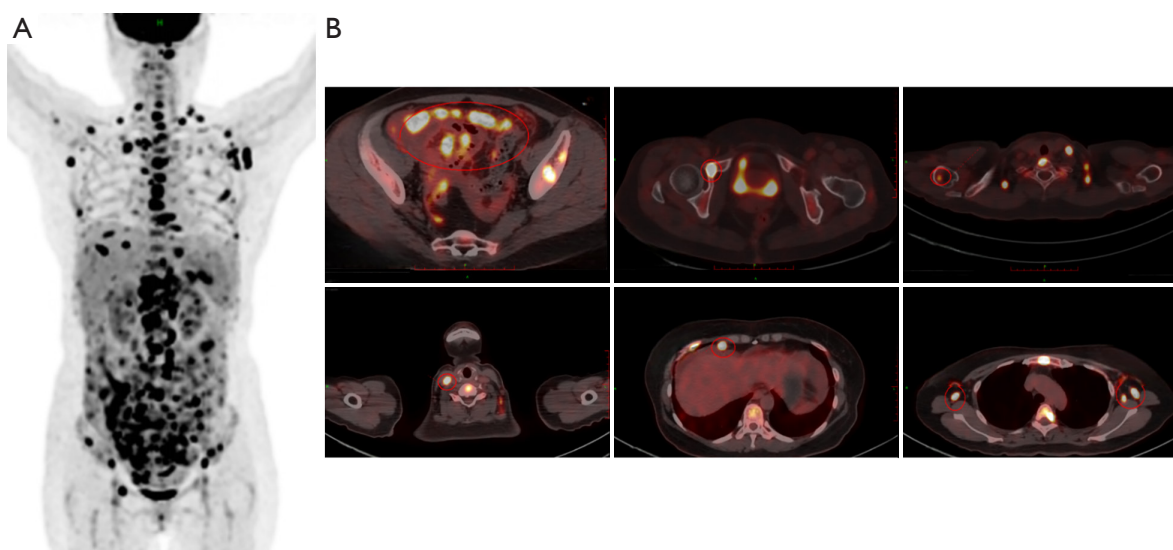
Results of the patient's whole-body PET-CT examination. (A) PET-CT showed multiple enlarged lymph nodes posterior to the right sternocleidomastoid muscle, bilateral posterior cervical triangle, bilateral clavicular region, bilateral axilla, anterior mediastinum, the region anterior to the right diaphragm, the lesser omental sac, splenic hilum, abdominal aorta, and mesenteric region; some of the enlarged lymph nodes had uneven density, indicating an abnormal increase in FDG metabolism. (B) Abdominal pelvic effusion, as well as thickening of the peritoneum, mesangium, and omental membrane and increased abdominal fat density, was accompanied by a diffuse nodular thickened shadow and increased FDG metabolism in many bones of the body but no obvious bone destruction. PET-CT, positron emission tomography-computed tomography; FDG, ^{18}F -fluorodeoxyglucose.
